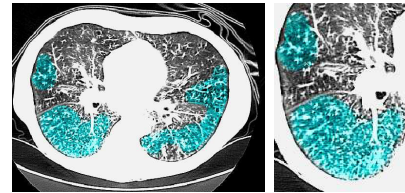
(Left) CT image with a significant amount TIB patterns. TIB patterns are labelled in blue. (Right) Zoomed window on the right lung.
